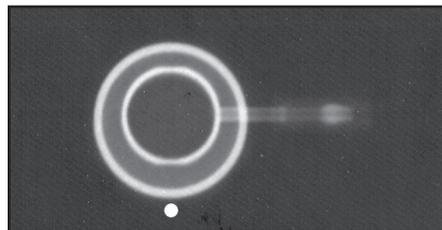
Top or bottom view x-ray image of the LAP-BAND AP® System Standard Access Port
